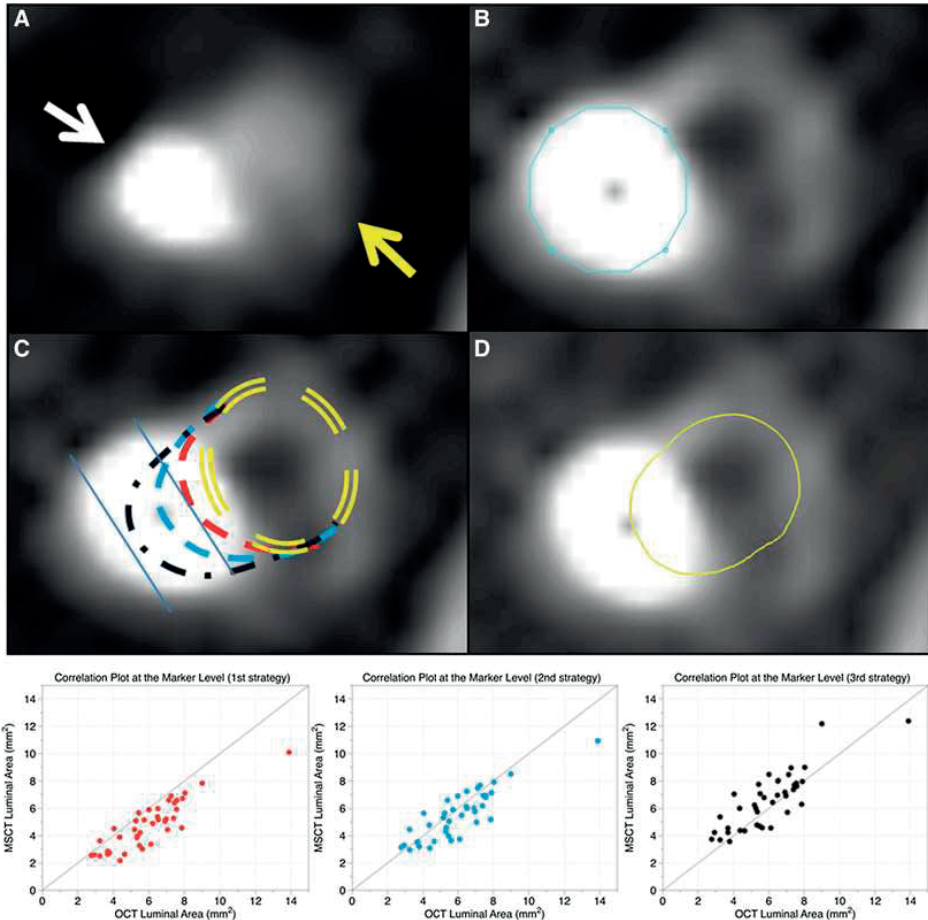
a) Cross-section at the level of the radiopaque marker with the blooming artefact (white arrows) and the coronary artery lumen (yellow arrow). b) CT-gradient image at the same cross-section, the radiopaque marker (blue line, area of 2.5 mm²) is readily identified. c) Three strategies evaluated to measure the agreement between coronary CTA and OCT derived luminal areas (yellow double dash lines represents the position of the lumen with respect to the marker artefact); the first strategy in red dash line included in the luminal area 1.1 mm² of the blooming artefact without crossing the center of the marker; the second strategy in blue dash line included 2.3 mm² of the blooming artefact and crossed the center of the marker and the third strategy in black dash line included 3.2 mm² of the blooming artefact and the center of the marker. d) Contour tracing methods with the best agreement (second strategy, blue line) with the OCT-derived matched lumen area. In the bottom, the three tracing strategies are plotted against the OCT-derived lumen area. CTA computed tomography angiography, OCT optical coherence tomography
